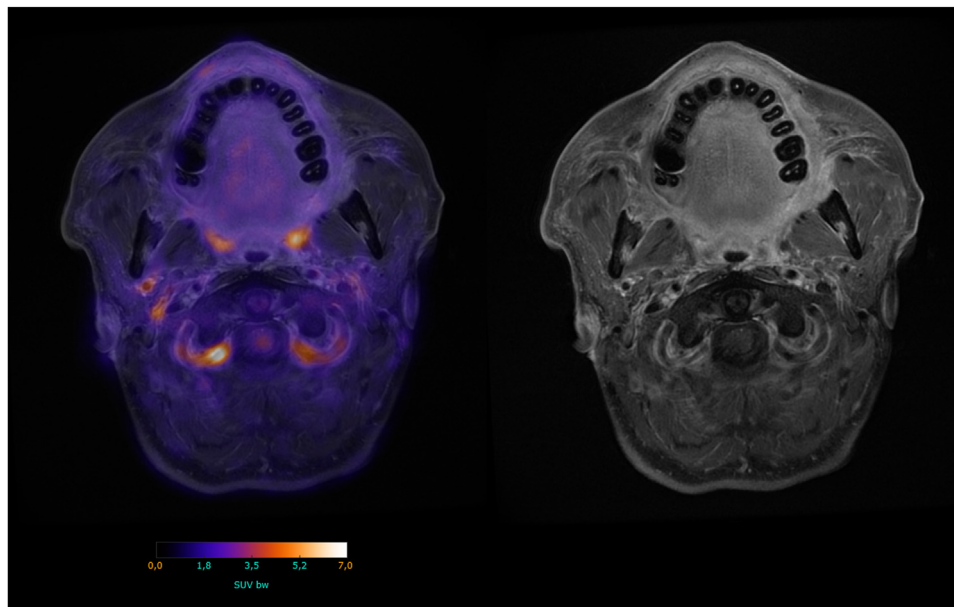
FDG PET/MRI in cranial GCA. Left: Axial fused FDG-PET/MRI image of a patient with cranial GCA. Increased uptake can be observed in the vertebral arteries, the proximal segment of the occipital arteries, and the right external carotid artery. Right: Axial MRI image (contrast enhanced T1-weighted) without FDG-PET. Vessel wall thickening and attenuation can be observed in the right external carotid artery and vertebral arteries.
